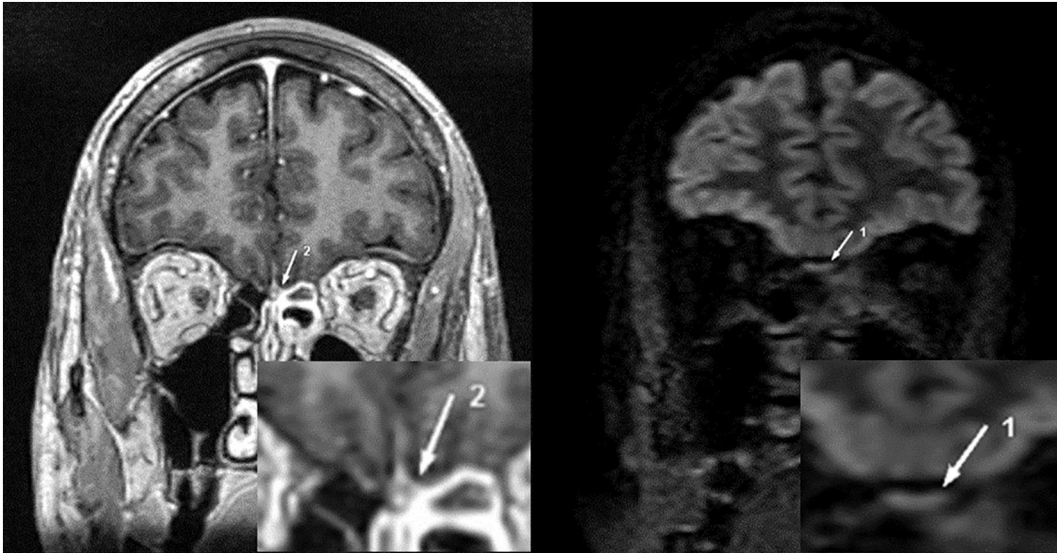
Left: Brain MRI. T1-BRAVO Coronal slice with paramagnetic contrast. The white arrow (2) points the olfactory bulbs, showing bilateral contrast enhancement. Right: Brain MRI. T2/FLAIR Coronal slice. The white arrow (1) points the olfactory bulbs, showing bilateral T2 hyperintensity.
